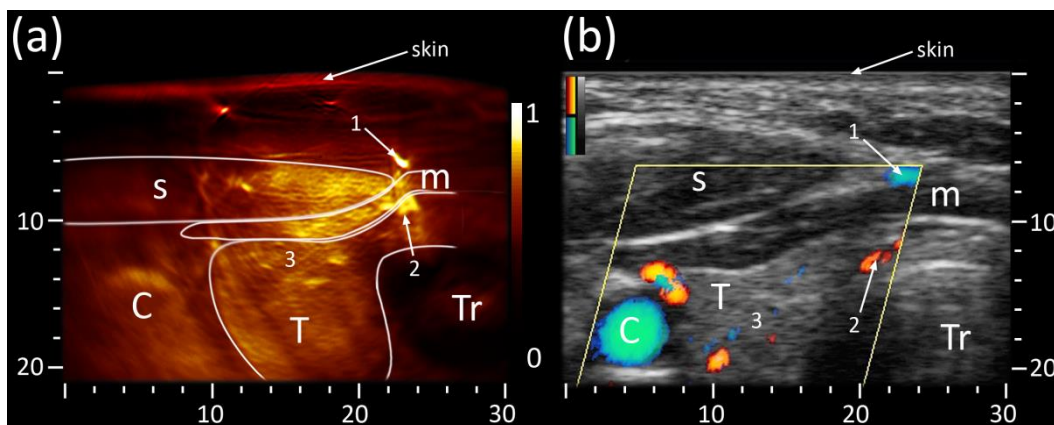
(a) Optoacoustic and (b) ultrasound cross-sections of the left thyroid lobe of the first volunteer. The optoacoustic image, leveled and normalized from 0 to 1, shows with high sensitivity vascular features of skin, muscles (1,2) and within the thyroid lobe (3). The corresponding ultrasound image in grayscale also depicts Directional Power Doppler signals superimposed in color (red/blue colormaps indicating opposite flow directions). C: Carotid, T: Thyroid, Tr: Trachea, s: sternocleidomastoid muscle, m: infrahyoid muscle; axes in mm.
